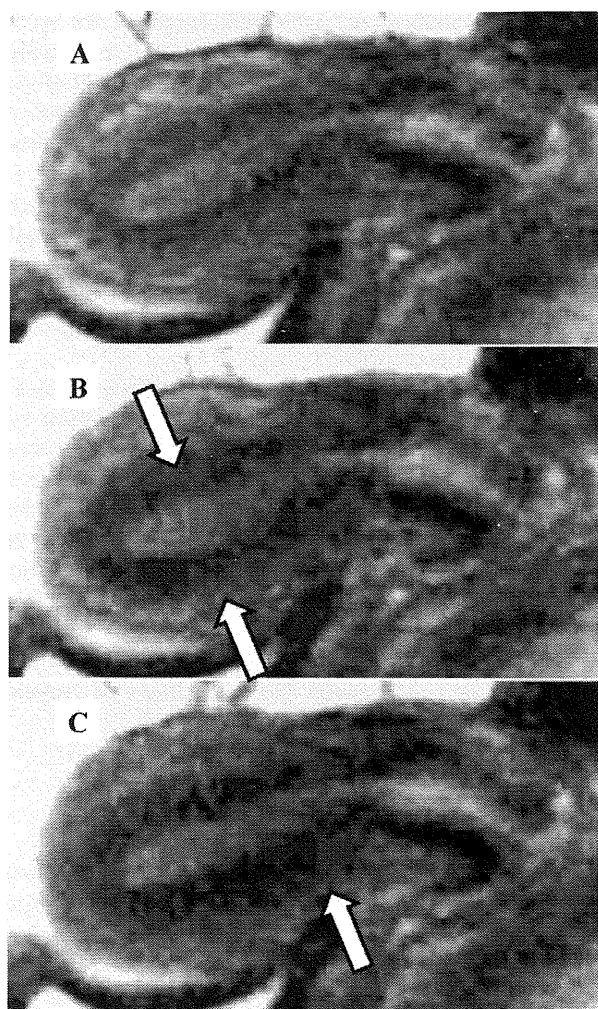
Serial single-shot fast spin-echo (SSFSE) T2-weighted images show subtle changes in the appearance of the junctional zone. (A) The entire junctional zone is thin compared with that observed in B and C. (B) The junctional zone exhibits focal thickening in the upper portion of the corpus (arrows). (C) The thickest portion of the junctional zone moved close to the cervix (arrow).
